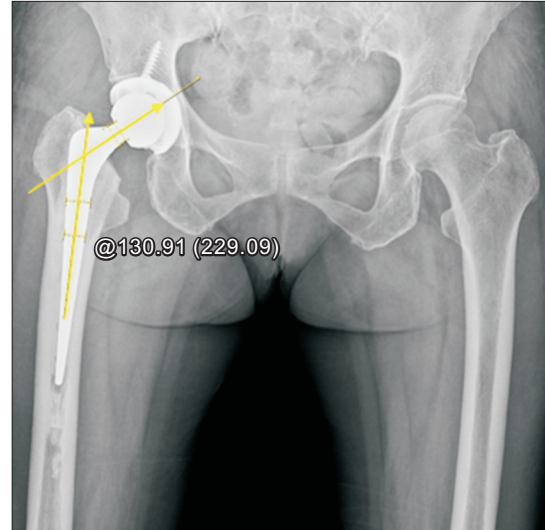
Femoral stem version: $\arcsin(\tan[\text{NSA}] / \tan[\text{TNSA}])$. It is calculated from an anteroposterior hip radiograph using rotation-based change in the projected prosthetic NSA. NSA: neck shaft angle, TNSA: true neck shaft angle.
